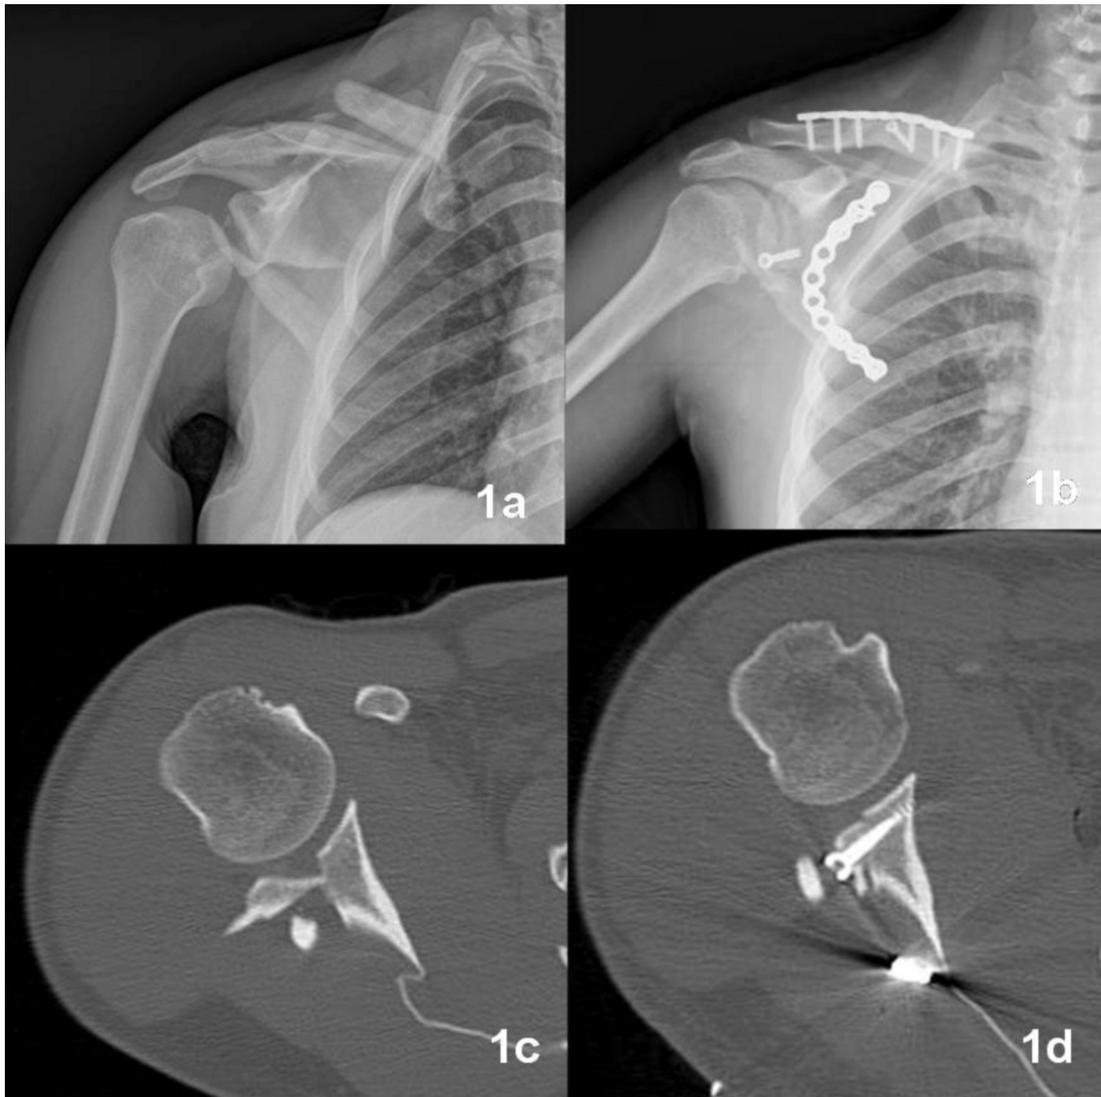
(1a) Preoperative x-ray examination, (1b) Postoperative x-ray examination, (1c) Preoperative CT imaging, (1d) Postoperative CT imaging.
